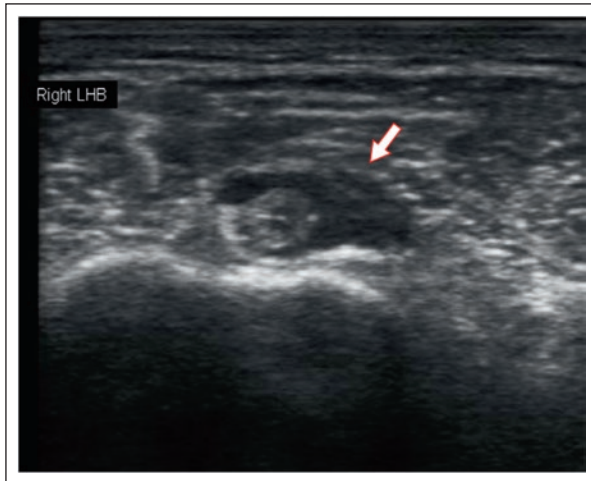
US grayscale of the shoulder of a 63-year-old man with ESRD with 21 years of hemodialysis and a limited range of motion of both shoulders. The transverse view of the right LHB tendon and its sheath showed a thickening of 6.8 mm and non-homogeneous echogenicity (arrow). The diagnosis was tendinosis of the right LHB tendon. ESRD: end-stage renal disease; LHB: long head biceps; US: ultrasound.
